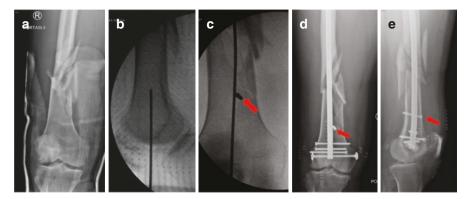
(a) Preoperative radiograph demonstrating a comminuted extra-articular fracture of the distal femur in a 64-year-old male involved in a high-speed motorcycle accident. (b and c) Intraoperative photographs demonstrating closed reduction of the fracture, starting guidewire insertion and placement of a 5 mm blocking screw
